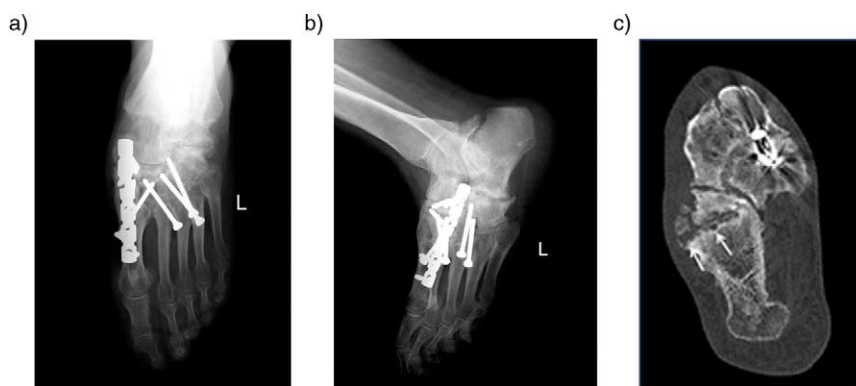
Midfoot reconstruction in a 60-year-old patient with unstable neuropathic osteoarthropathy (a–c). Anteroposterior (a) and lateral (b) plain radiographs demonstrated neuropathic changes in midfoot region and complex realignment and fusion (a). Joint destruction osseous fragmentation and subchondral cyst formation (arrow) better delineated compared to PR in transverse CT image (c).
